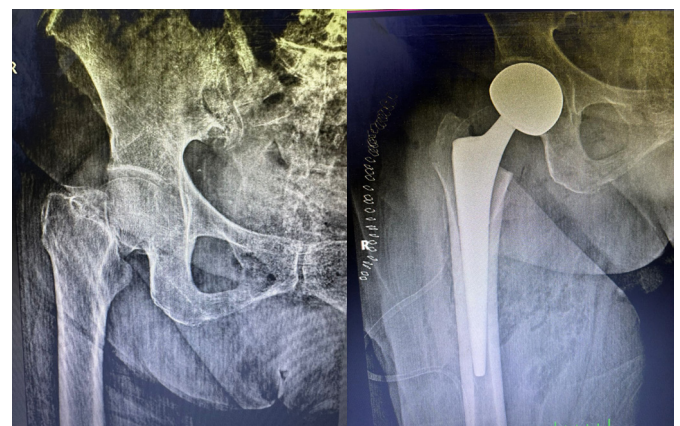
Preoperative radiographs of a 79-year-old female patient who underwent BHA due to femoral neck fractures (A); postoperative posterior-anterior radiographs (B)
